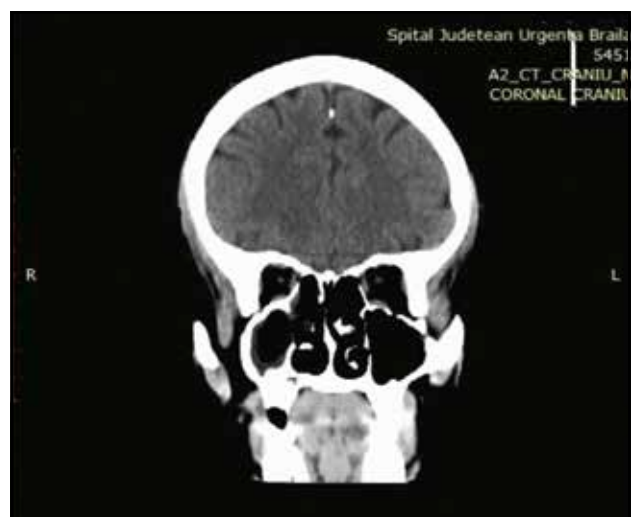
Native cranio-facial CT examination (axial, coronal sections) 8 days postoperatively: the significant reduction of changes in the right pansinusitis, the edematous periorbital cellulitis as well as exophthalmia.
